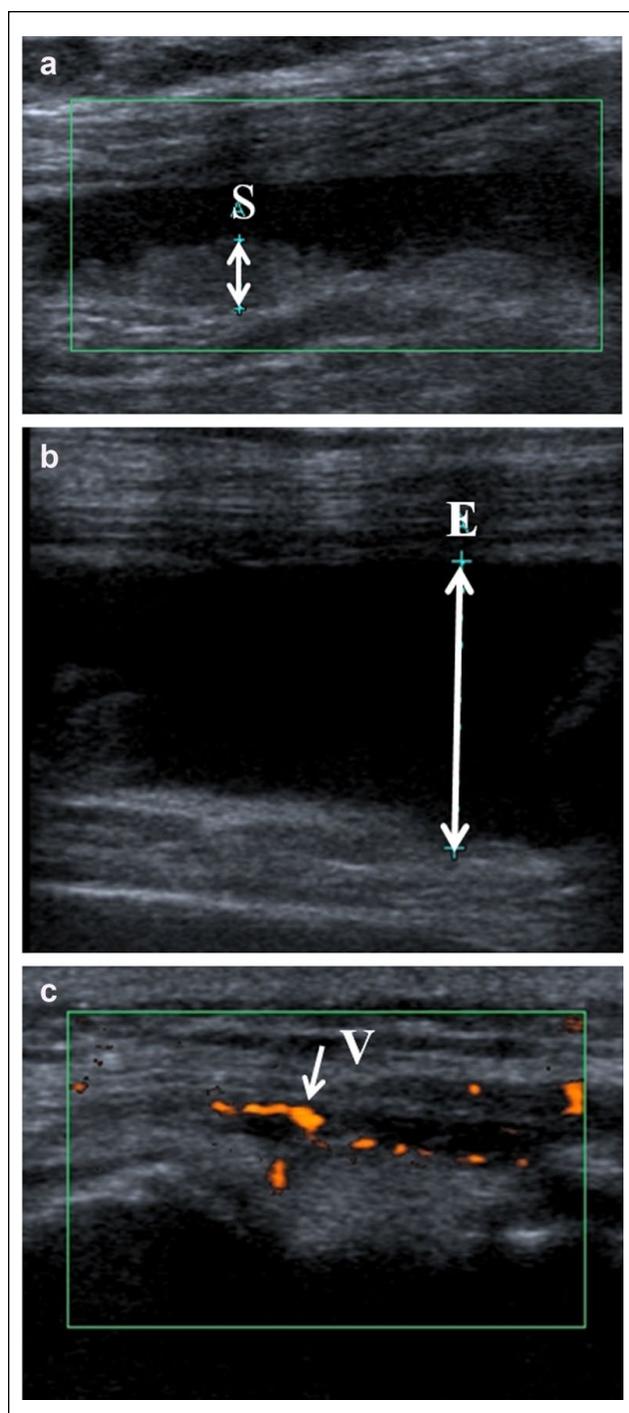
Ultrasound images of the knee of a person with OA: (a) synovial hypertrophy (S), (b) increased depth of synovial effusion (E), and (c) increased vascularity (V) demonstrated by power Doppler signal. Image credit: A. Sarmanova.
